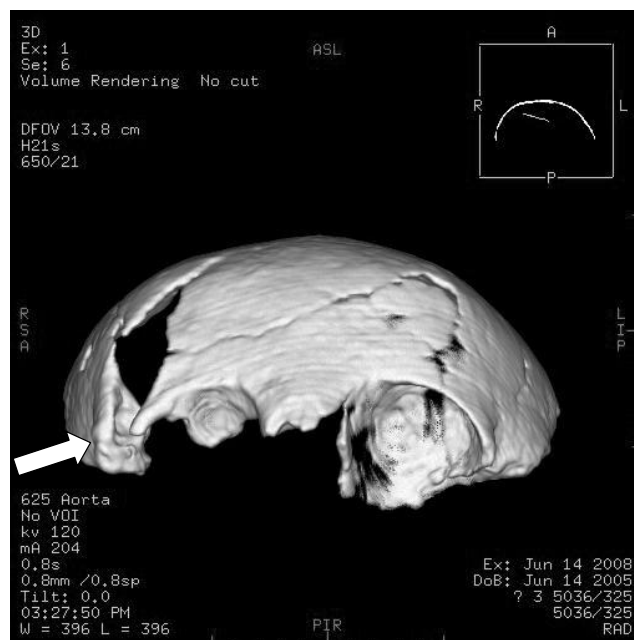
Frontal bone observed by 3D-CT confirmed different bone densities around the area affected by the lesion
